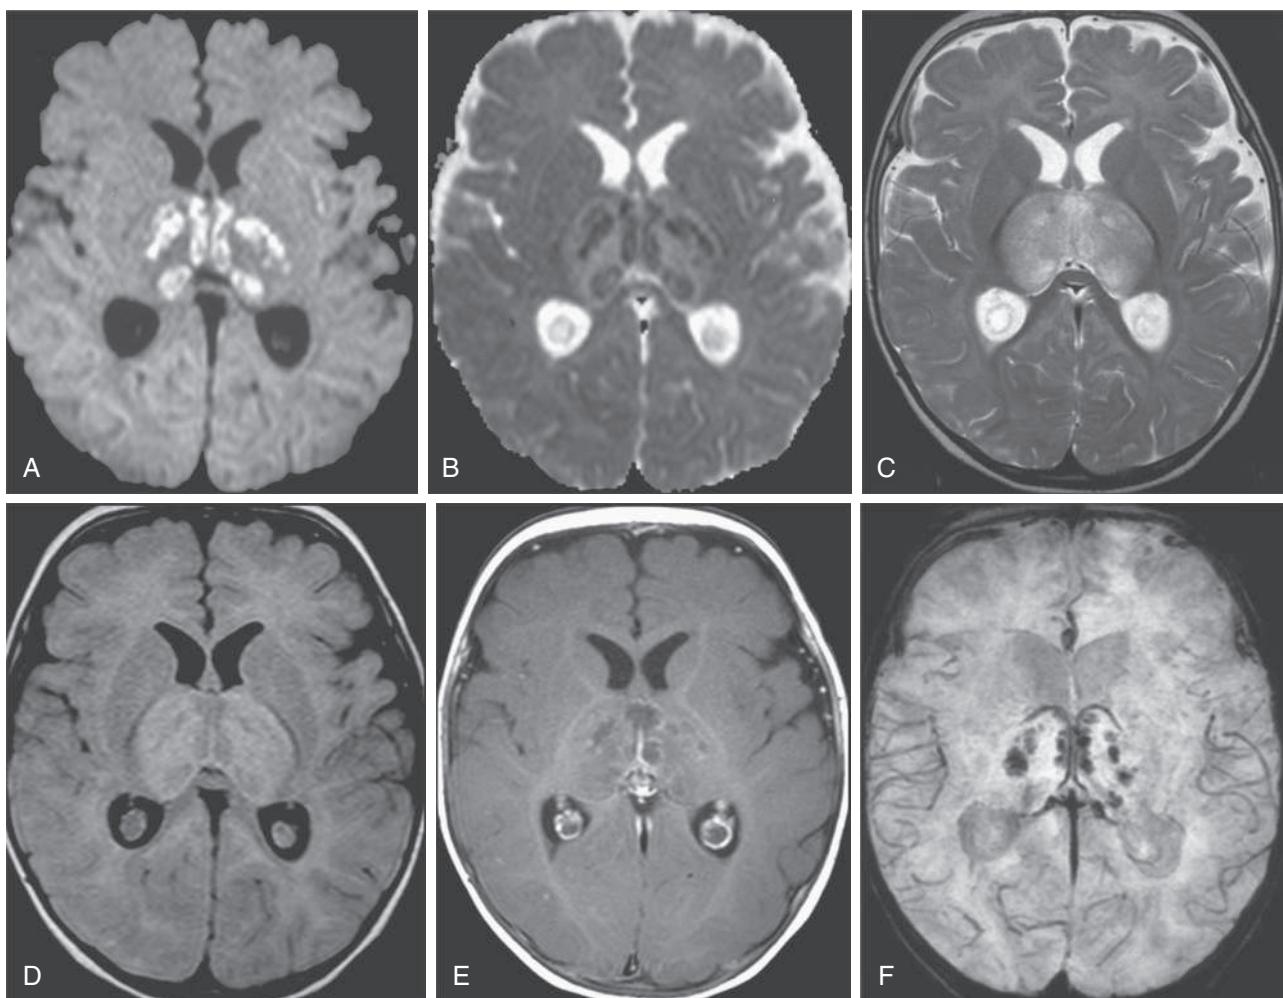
Acute necrotizing encephalopathy. MRI at presentation. A, Axial diffusion-weighted image. B, Axial apparent diffusion coefficient (ADC) map. C, Axial T2-weighted image. D, Axial fluid-attenuated inversion recovery (FLAIR) image. E, Contrast-enhanced axial T1-weighted image. F, Axial susceptibility weighted image. Diffusion-weighted images (A) and corresponding ADC map (B) clearly show multiple areas of restricted diffusion against a background of increased diffusion involving both thalamus, which are swollen. On T2-weighted (C) and FLAIR (D) images, the thalamus are markedly swollen and hyperintense. On T1-weighted images obtained after intravenous gadolinium chelate injection (E), multiple necrotic portions are well delineated by peripheral faint, linear enhancement. Incidental choroid plexus cysts are detected. Susceptibility weighted image (F) shows multiple hypointense spots, consistent with petechial hemorrhage. (From Bergamino L, Capra V, Biancheri R, et al. Immunomodulatory therapy in recurrent acute necrotizing encephalopathy ANE1: is it useful? *Brain Dev*. 2012;34:384–391, Fig. 1.)
